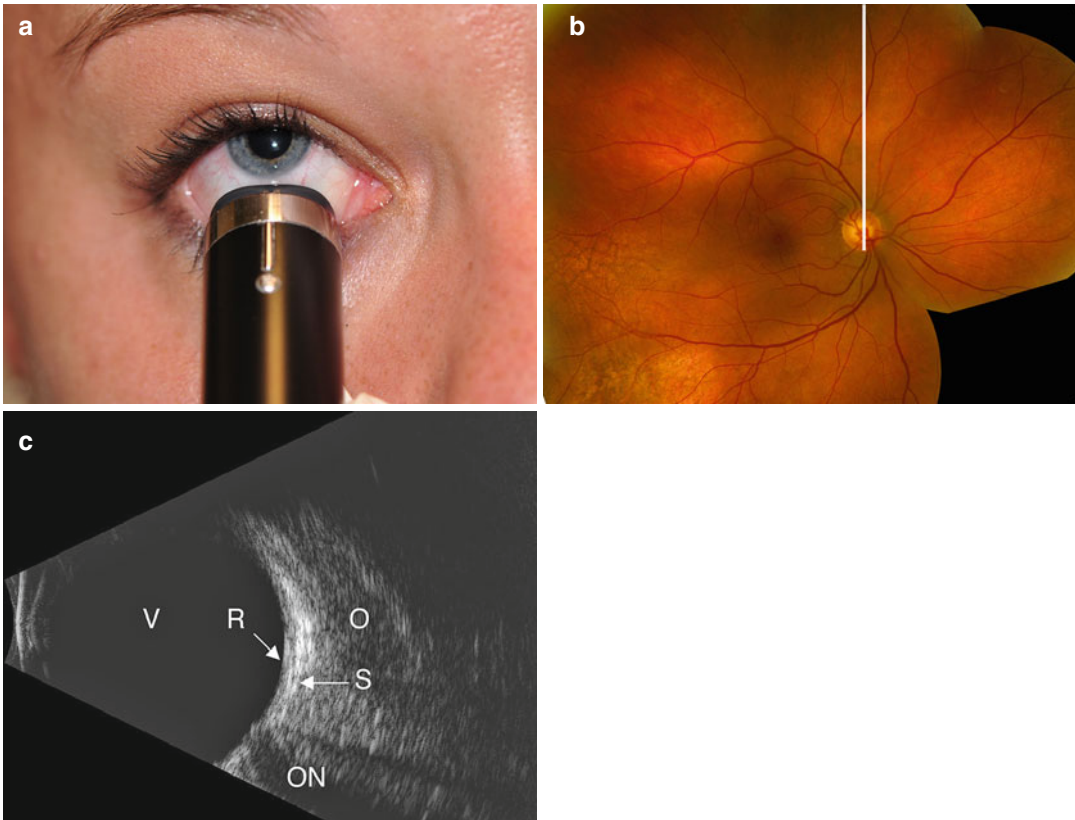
Longitudinal B-scan position. B-scan probe tip placed on the conjunctiva near the limbus with the marker pointed superiorly (a). Corresponding ultrasonographed fundus (b, line). Resulting B-scan image showing a radial
